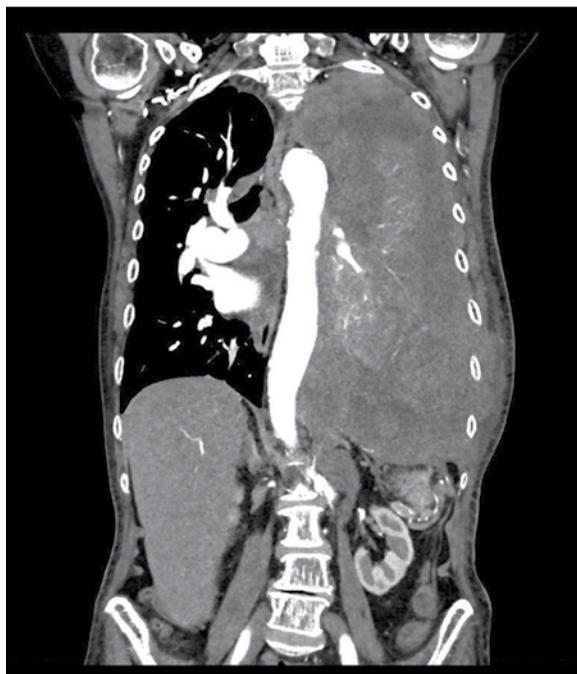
Chest CT, MPR reconstruction. Huge left pleural masses, that compress lung and extend to abdomen.
